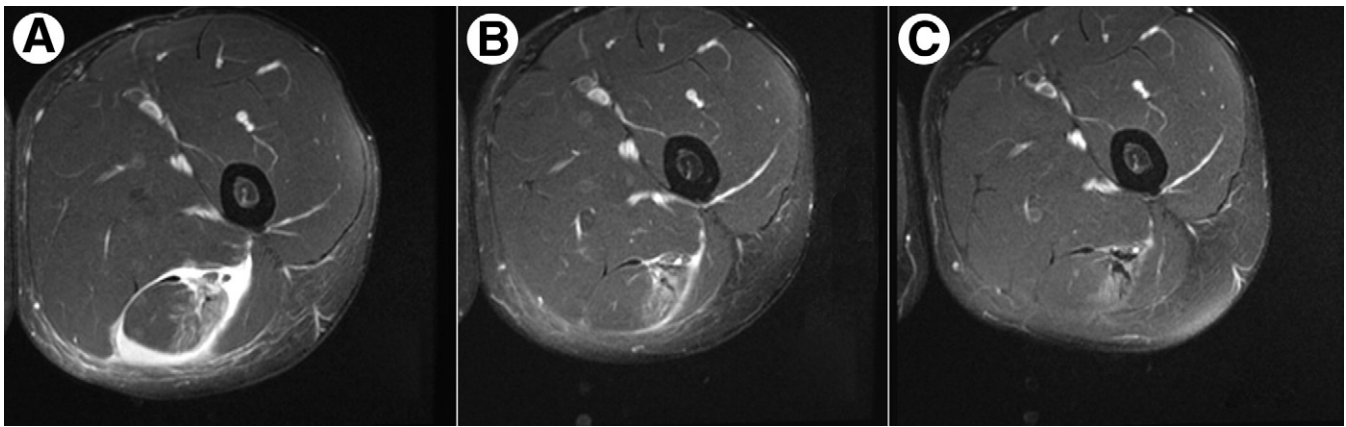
A young soccer player with a biceps femoris tear was treated every other week with 2 PRP injections. (A) Axial MRI reveals increased T2 signal intensity with disruption of the biceps femoris tendon and perifascial fluid, consistent with a grade II injury; (B) two weeks after the first PRP injection, the same axial level shows less fluid and muscle edema with some healing tissue; (C) outcome three weeks after the second injection (at five weeks from the beginning of the treatment): the same axial level shows no fluid, a faint edema and plenty of scar tissue in miotendinous unit of the biceps femoris tendon.
